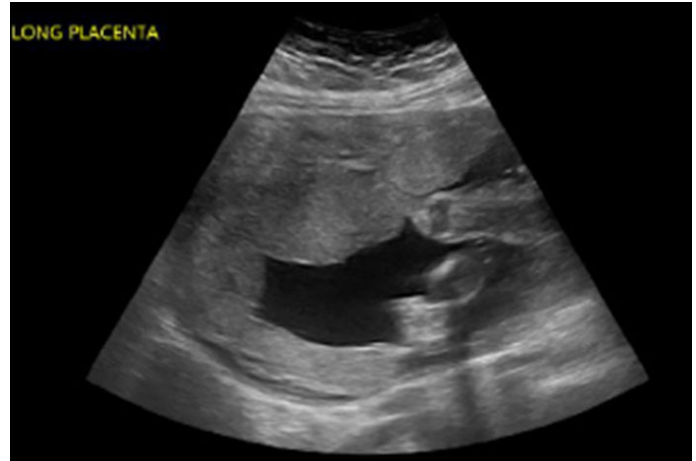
Ultrasound at 22w6d of IVF pregnancy demonstrating smaller, dilated vessels in anterior myometrium.
